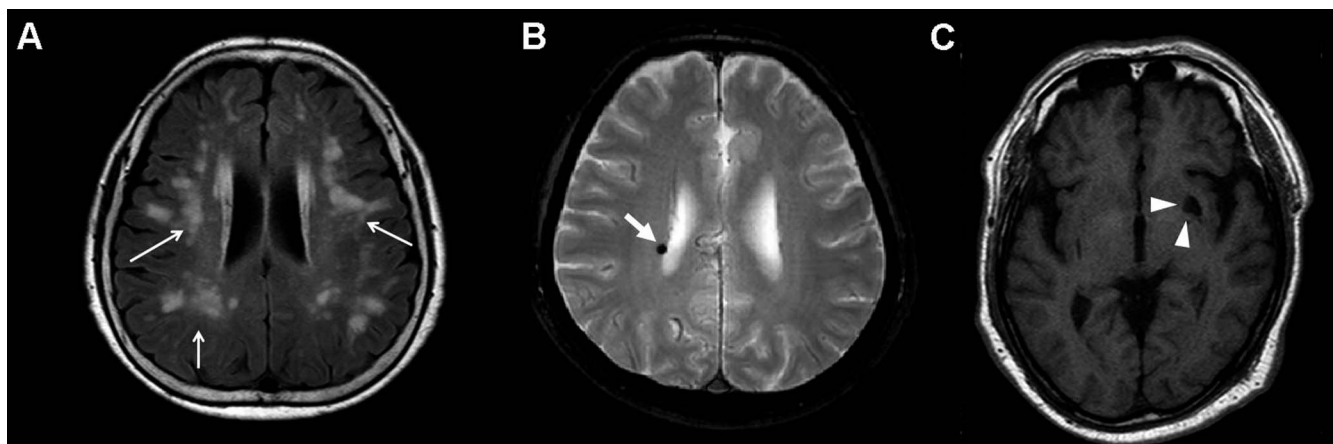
Representative brain MRI of cerebral small vessel disease in patients with branch retinal artery occlusion (BRAO). (A) White matter hyperintensities on MRI (FLAIR image), classified grade 3 by Fazekas scale (white arrows). (B) A cerebral microbleed shown in T2-weighted MRI (white arrow). (C) Silent lacunar infarct in the left thalamus in a T1-weighted MRI (white arrow). MRI, magnetic resonance image; FLAIR, fluid-attenuated inversion recovery.
